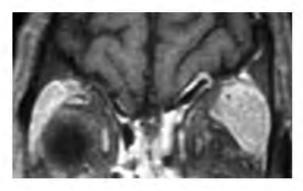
Coronal fat saturated contrastenhanced T1-weighted MR image shows diffuse homogeneous enhancement in both glands.
